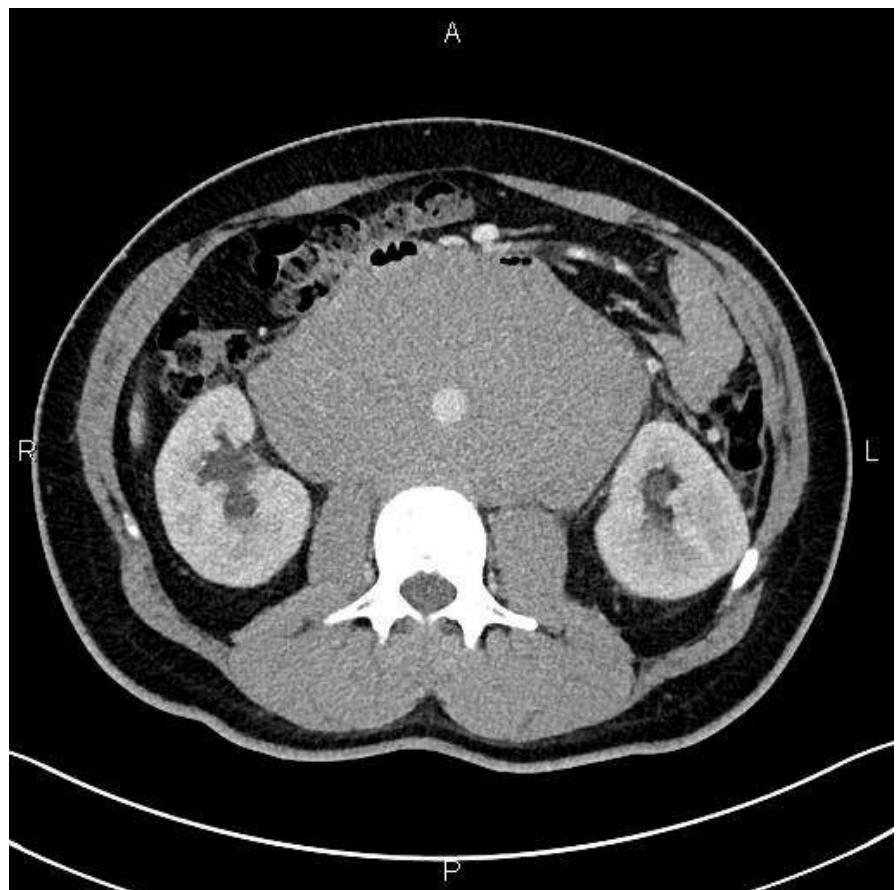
CT transversal.
